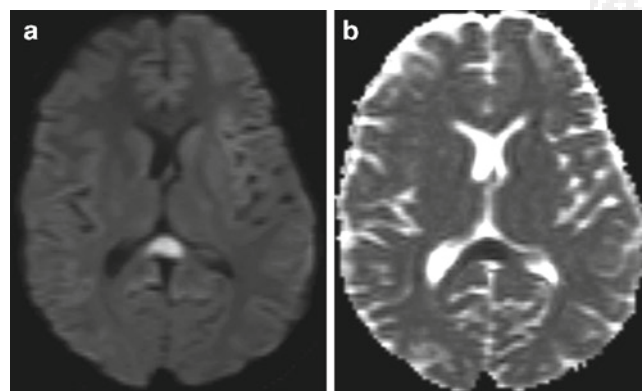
Transient splenial lesion associated with antiepileptic medication (valproic acid) treatment. (a) Axial DWI and (b) ADC images from a 16-year-old girl treated with antiepileptic medications for psychiatric illness and no history of seizures demonstrate restricted diffusion in the splenium of the corpus callosum. The abnormality resolved on follow-up MRI after discontinuation of the medication (*not shown*)
